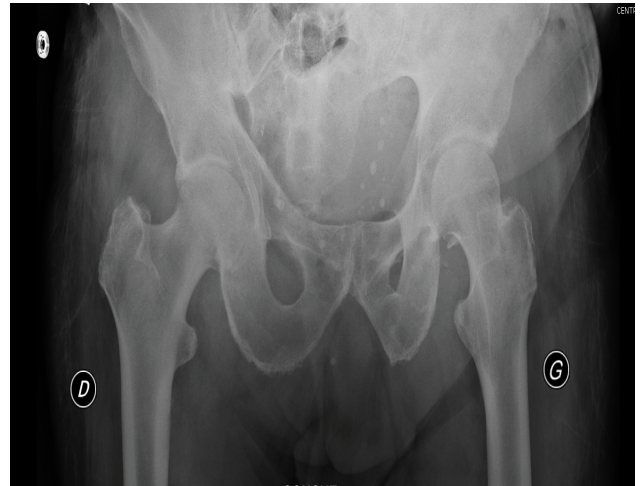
Control X-ray after 6 months follow-up.
